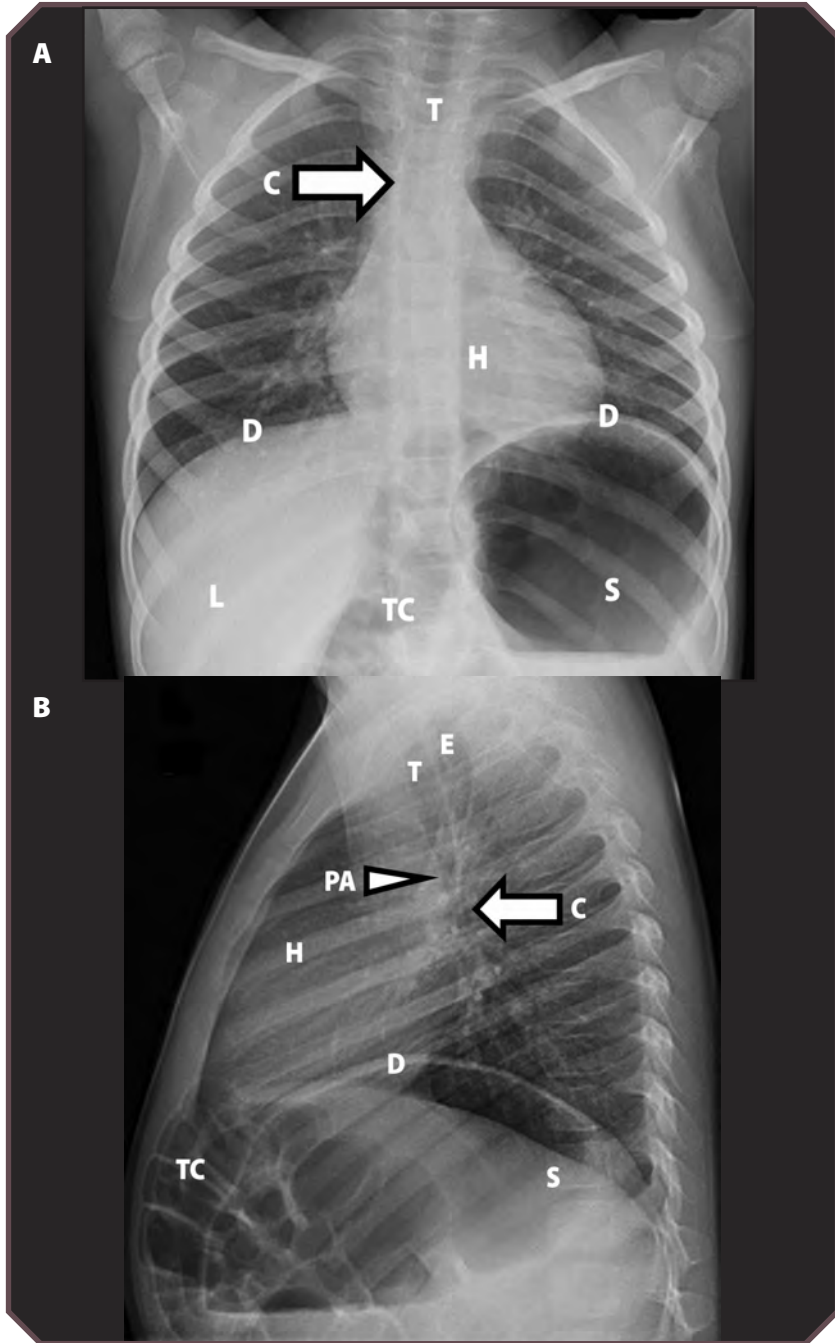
Normal chest radiographs in a 3-year-old boy. A. Frontal and B. lateral views show a normally sized heart (H), trachea (T), carina (C, arrows on A and B), stomach (S), diaphragm (D), liver (L), pulmonaary artery (PA, arrowhead on B), esophagus (E), and transverse colon (TC).
